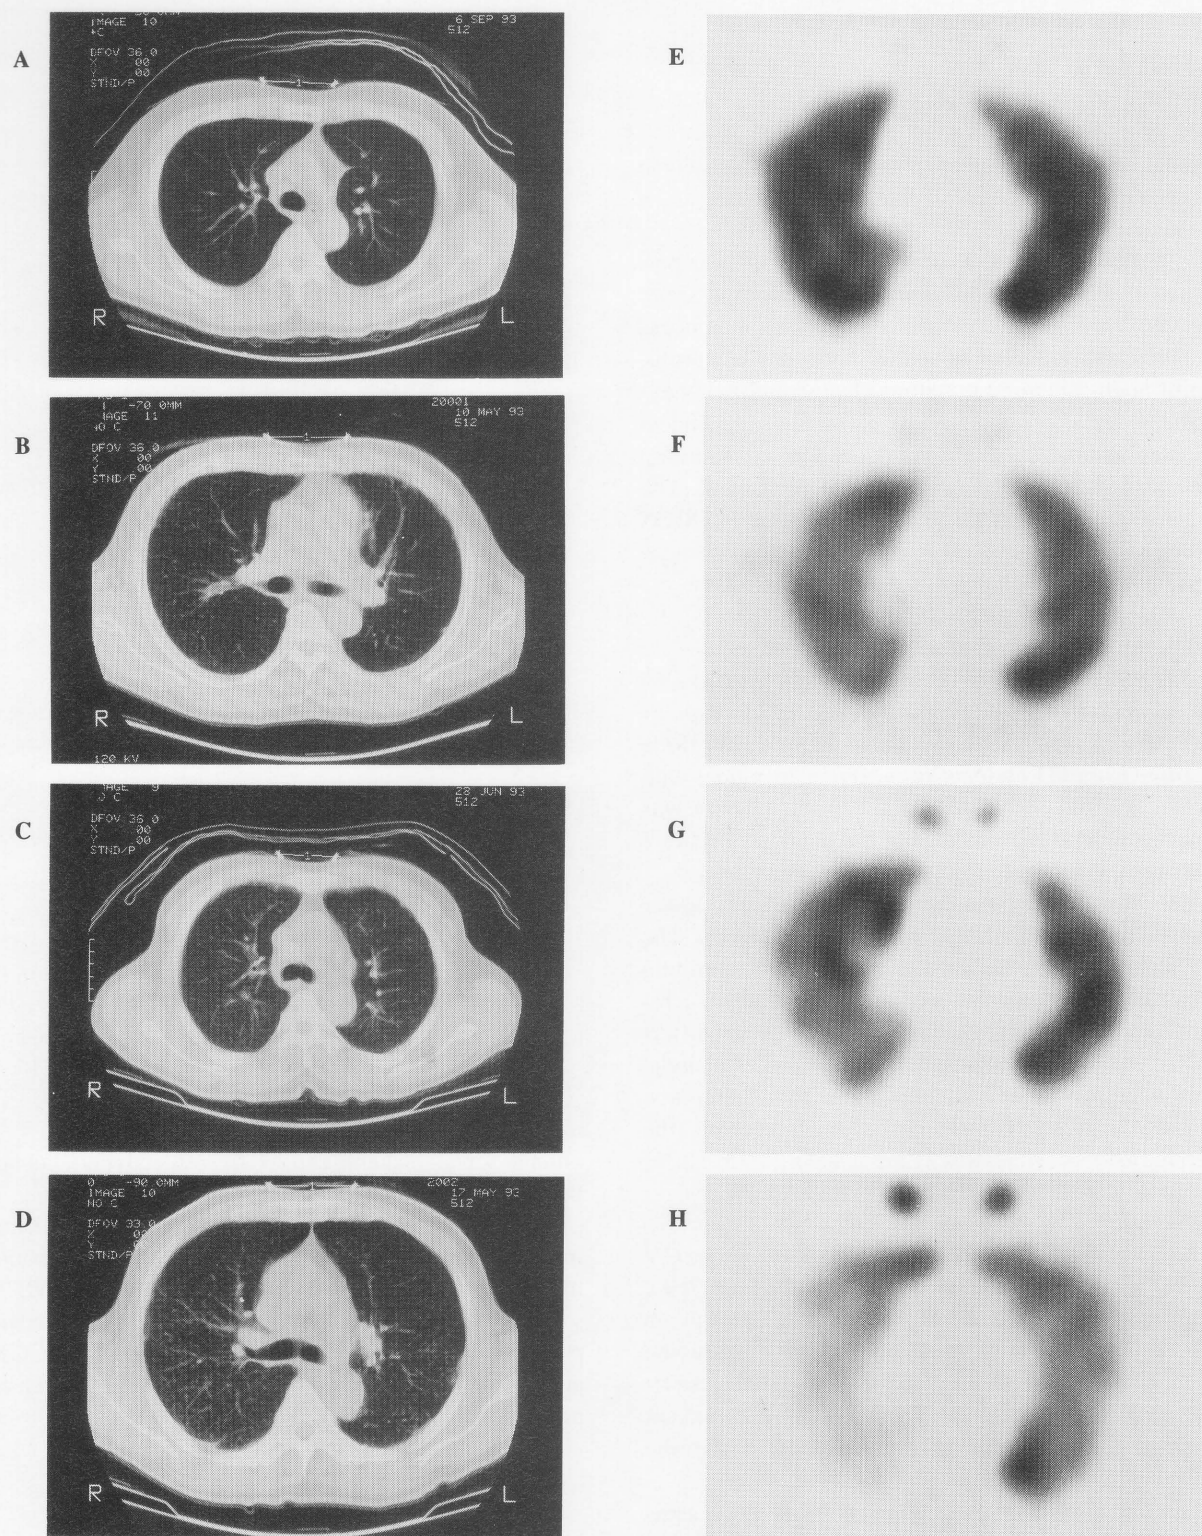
Image A to D are the images of CT and E to H are the images of ventilation SPECT. Both CT and SPECT images are obtained at same axial section. A and E are the images of control. B-D and F-H are the images of grade 1 to grade 3 of silicosis. Corresponding to the CT grade, the distribution of technegas is homogeneous in controls and becomes heterogeneous with the degree of silicotic lesion.
